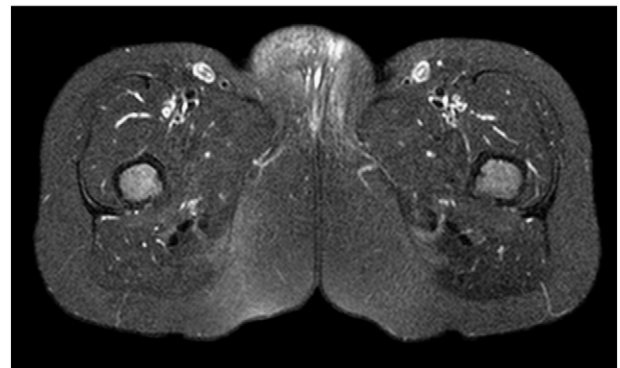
Fat-suppressed T2-weighted magnetic resonance image showing a swollen labium major with irregular high-signal intensities (case 1).
